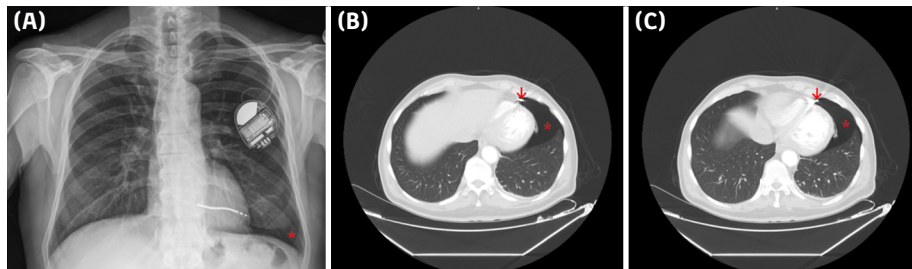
(A) Anteroposterior chest X-ray obtained at admission demonstrating a left-sided basal pneumothorax (red asterisk) and abnormal positioning of the implantable cardioverter-defibrillator (ICD) lead, with the lead tip nearly in contact with the left lung. (B, C) Chest computed tomography images demonstrating a left-sided pneumothorax (red asterisks) and a transvenous ICD lead (red arrows) that had perforated the apex of the right ventricle (RV) and migrated into the left pleural cavity.
